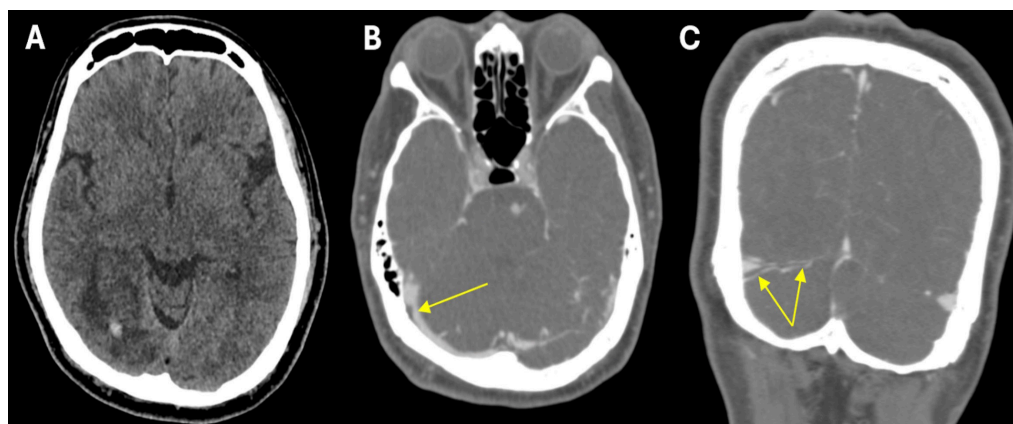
(A) Non-contrast CT brain demonstrated acute focal hemorrhage at the right occipital lobe with peri-hemorrhagic hypodensity extending to the right parieto-occipital region; (B) Subsequent CT venography in axial plane revealed thin linear isodensity within the right transverse sinus; (C) CT venography in coronal plane confirmed the filling defect within the right transverse sinus, consistent with thrombus
